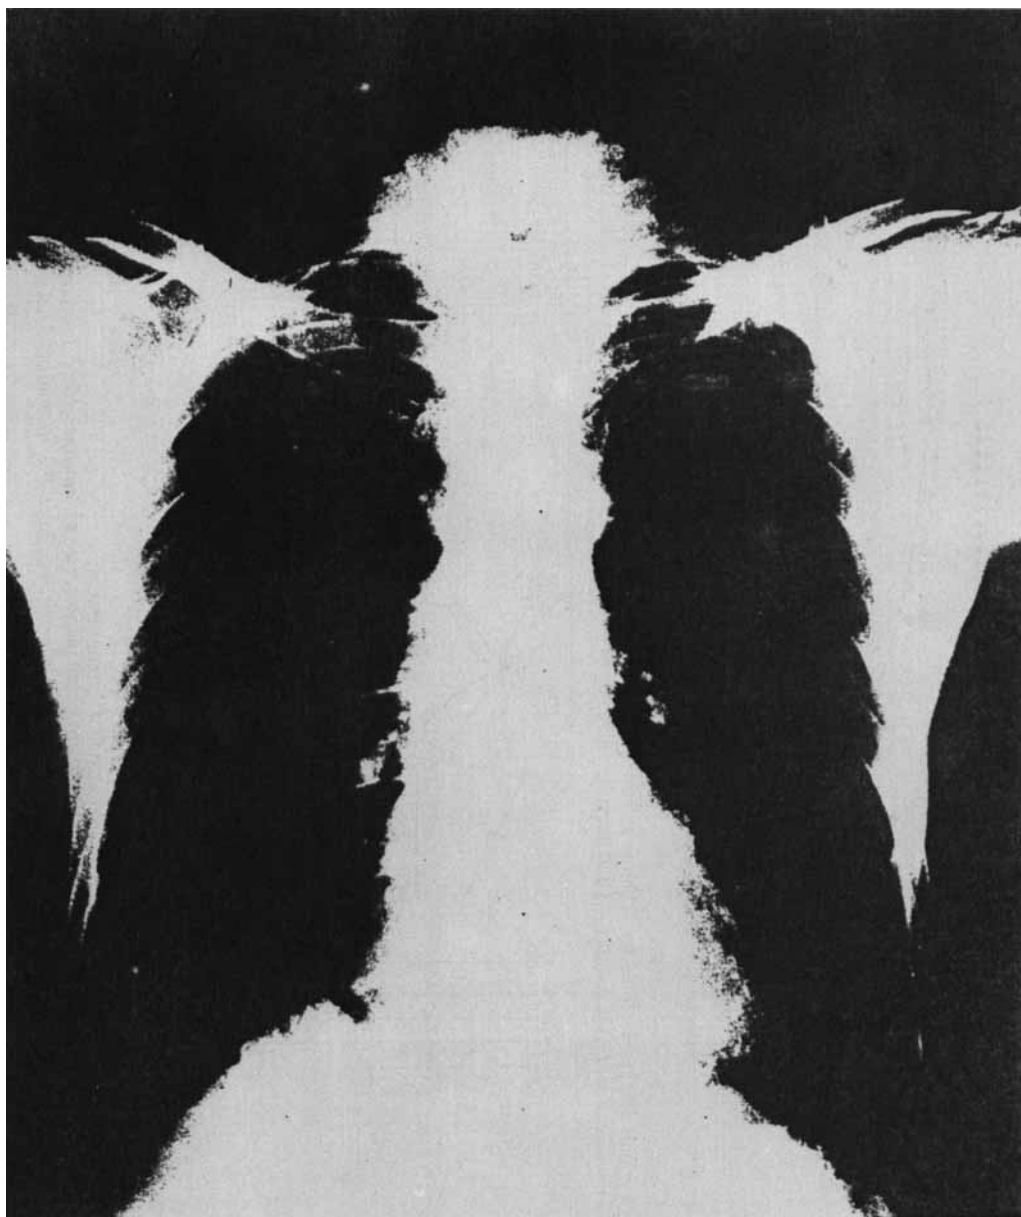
· Chest X-ray picture of this PSS patient after treatment with liposomal-SOD for 3 weeks.
